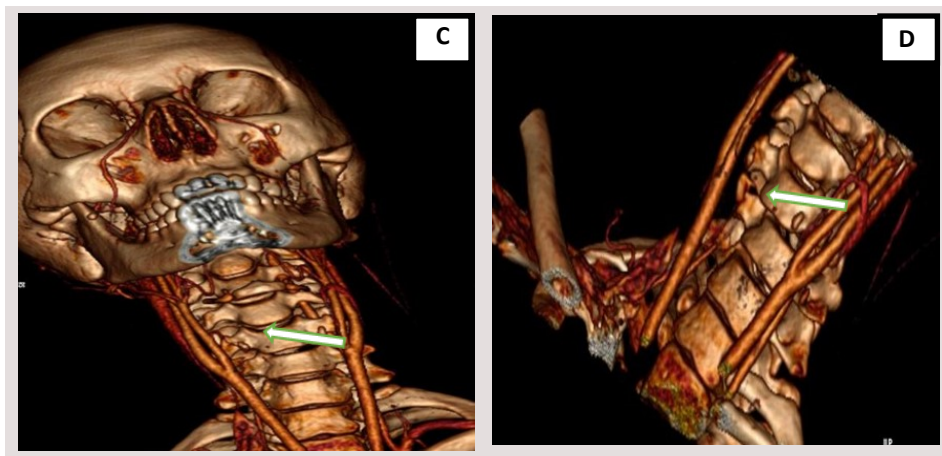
A&B - CT-angio -VRT of the cervical spine showing the occlusion of the right vertebral artery (the white arrows shows the absence of the right vertebral artery after the level of the injury).
